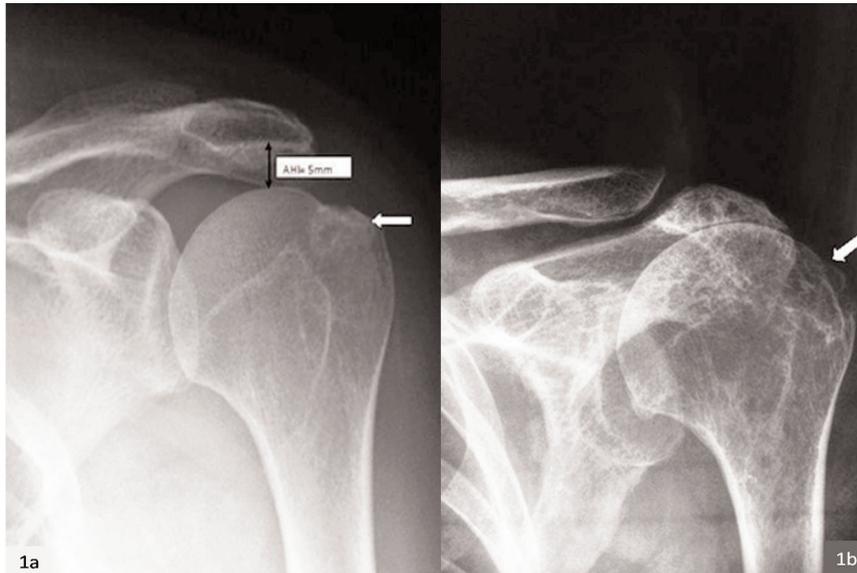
AP roentgenogram of the same patient at the initial presentation (a), and at the latest follow-up (b). The Grade 2 (AHI=5mm) rotator cuff tear progressed to Grade 4 (arthritic changes; glenohumeral narrowing) and the cyst (white arrow) at the greater tuberosity has enlarged after a 45 months followup.
